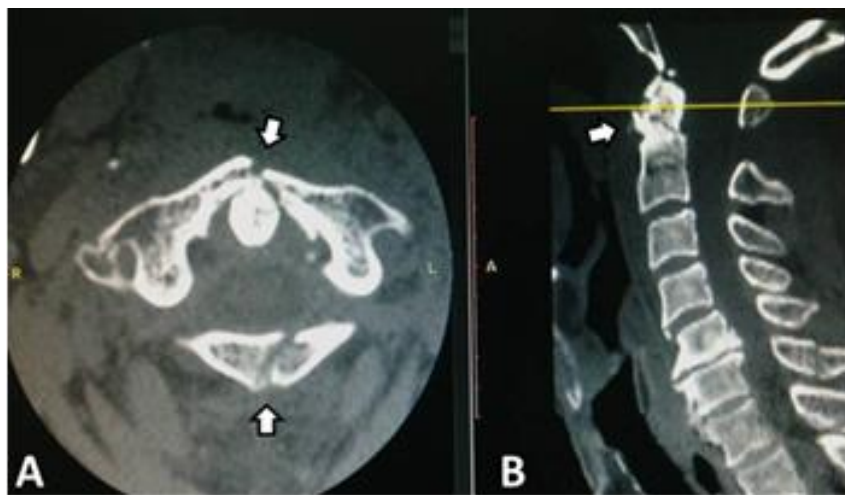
CT image of simultaneous fracture of C1 and C2 (type II): A/ Jefferson fracture; B/ C2 fracture (type II)
